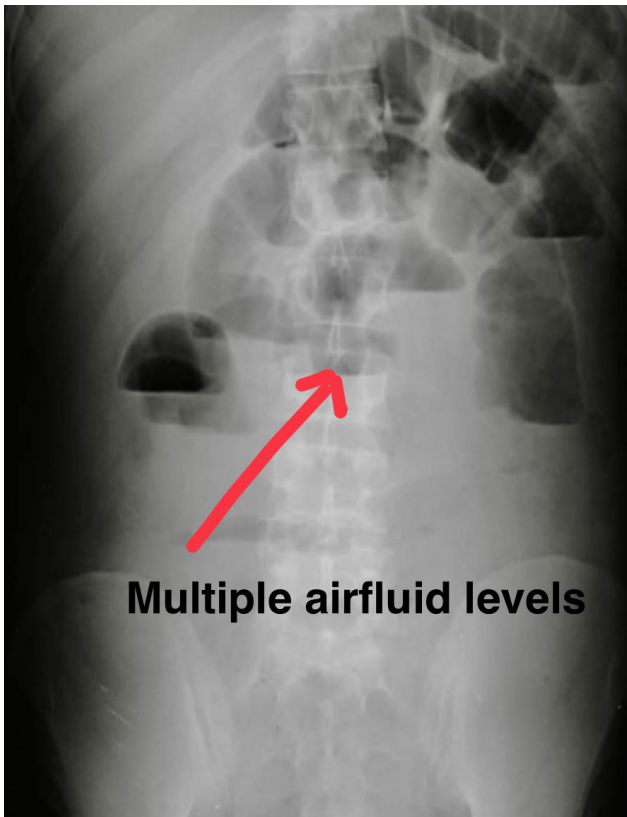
X-ray erect abdomen showing multiple airfluid levels.
